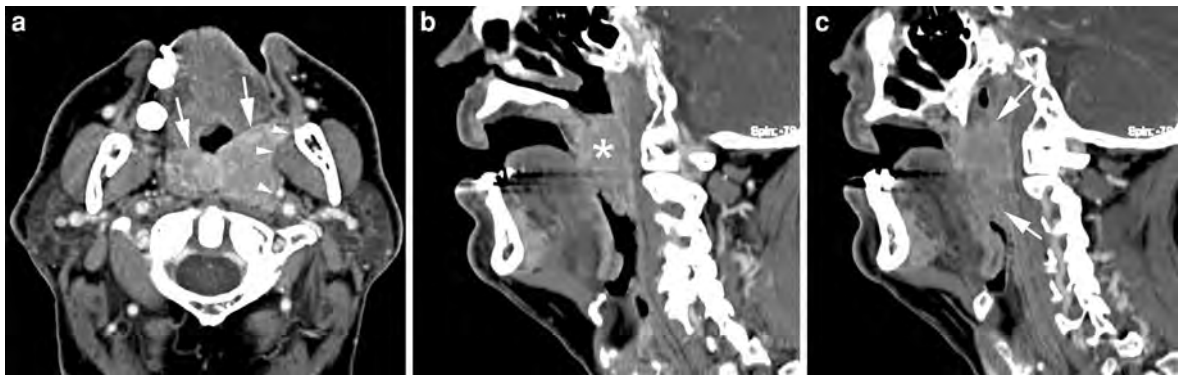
Contrast-enhanced CT-images in a patient with soft palate cancer. a Axial image. Pronounced thickening and increased enhancement of the soft palate (*arrows*); the mass extends into the region of the retromolar trigone, and pushes the left lateral pharyngeal wall towards the parapharyngeal space
